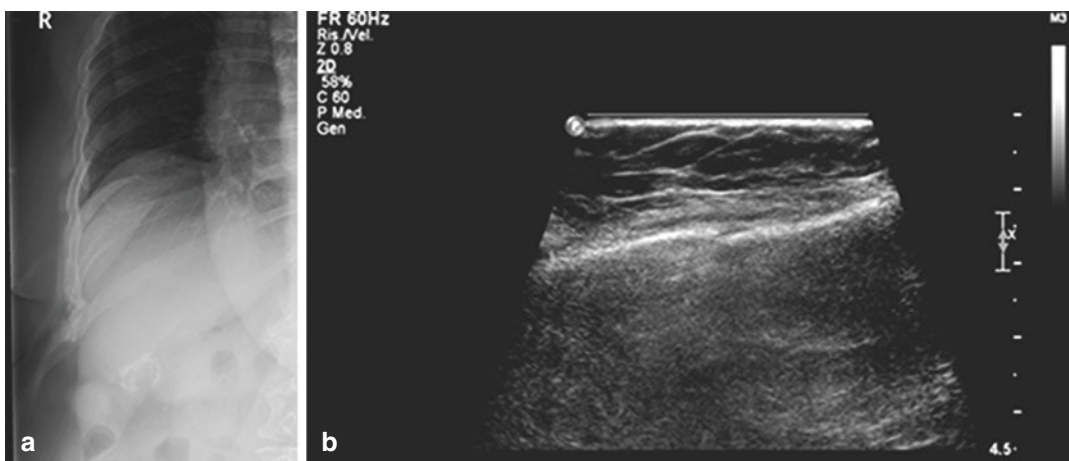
Uncertain cortical irregularity in X-ray examination (a) of the eighth right rib at middle axillary, promptly confirmed by the visualization of the cortical bone interrupted in ultrasound examination (b)
